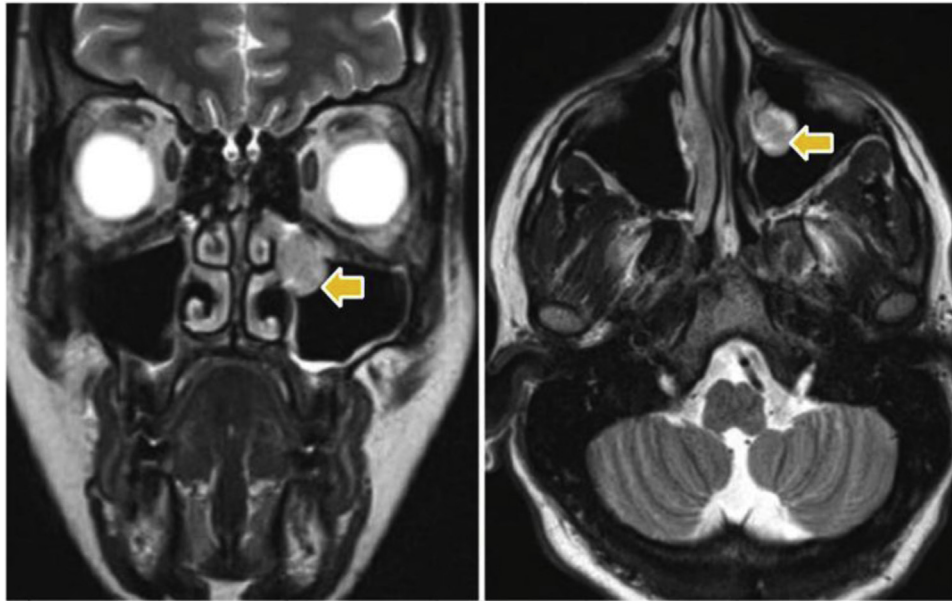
Magnetic resonance image of paranasal air sinus demonstrating tumor arising from the left maxillary sinus. A T2 intermediate mass is seen in the left maxillary sinus (yellow arrows).
